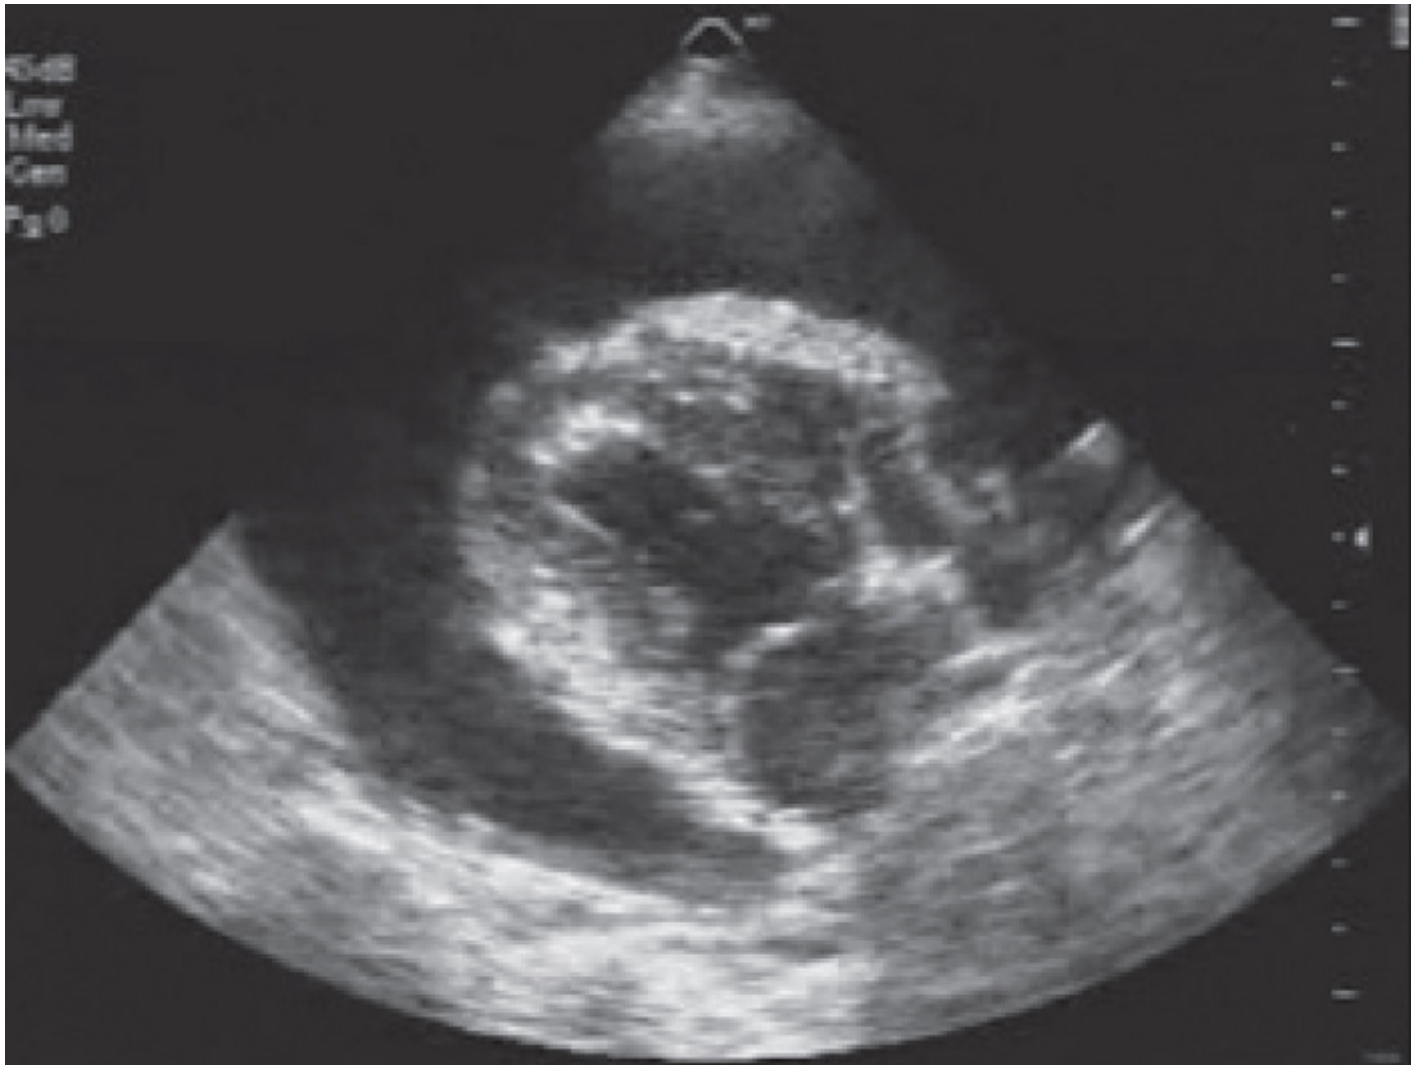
Right parasternal long axis echocardiogram of a bull mastiff with a pericardial effusion showing cardiac tamponade, with collapse of the right atrium.
